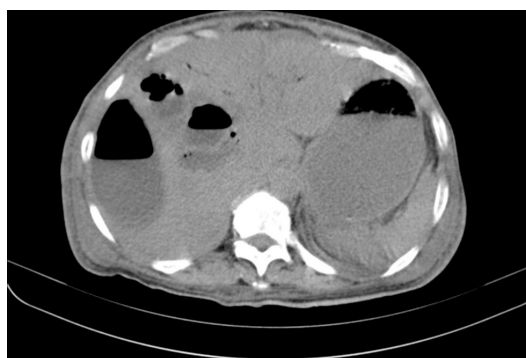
Thoracoabdominal CT scan, axial.
